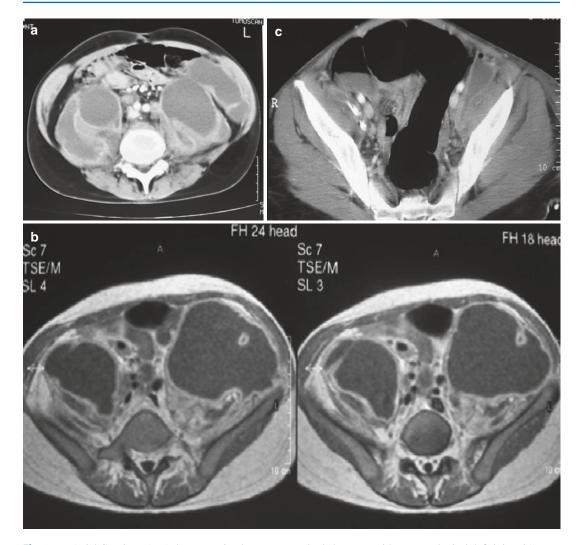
Axial CT views (\mathbf{a} - \mathbf{c}) demonstrating huge paravertebral abscesses without neurological deficit in a 21-yearold patient with L3–L4 spinal TB (Courtesy of P. Fernandes, M.D.)
